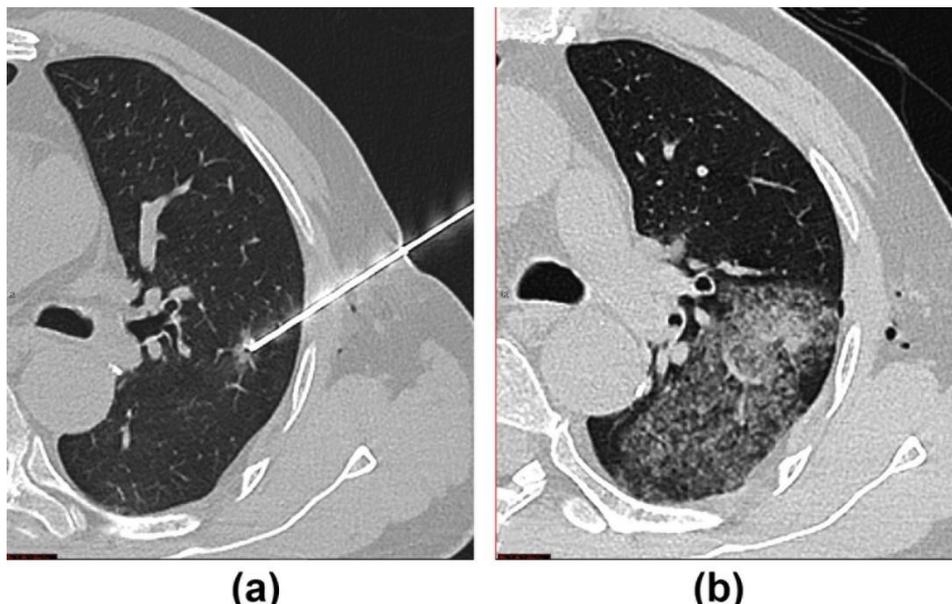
(a) A 54-year-old man with a 1.8 cm nodule in the left upper lobe. During PTLB, he was placed in the supine position. The lesion was approached from the anterior chest wall. An axial unenhanced CT image (lung window) acquired during the procedure shows the 17 G coaxial needle positioned adjacent to the lesion.
